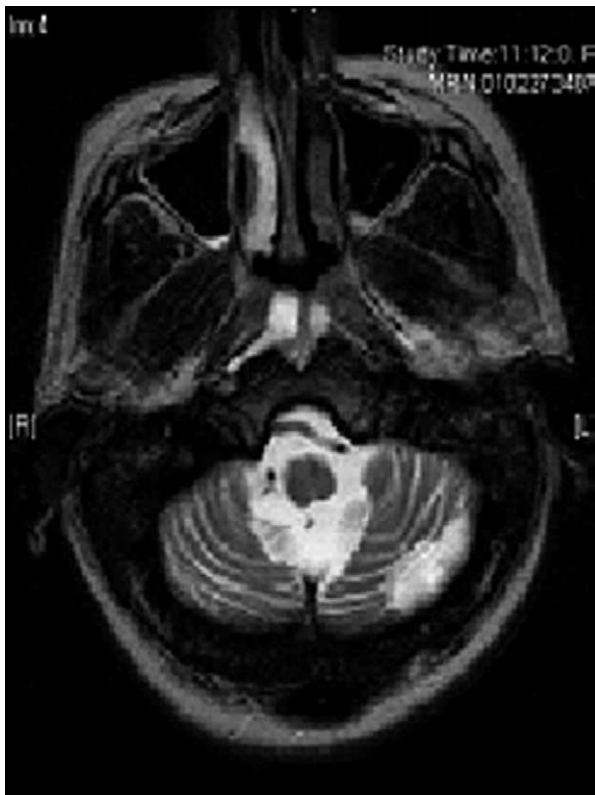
Magnetic resonance imaging of the brain demonstrating an isolated left posterior circulation infarction.
